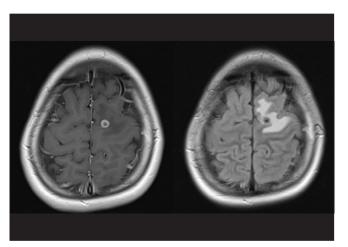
MRI brain scan (TI with contrast and FLAIR)
